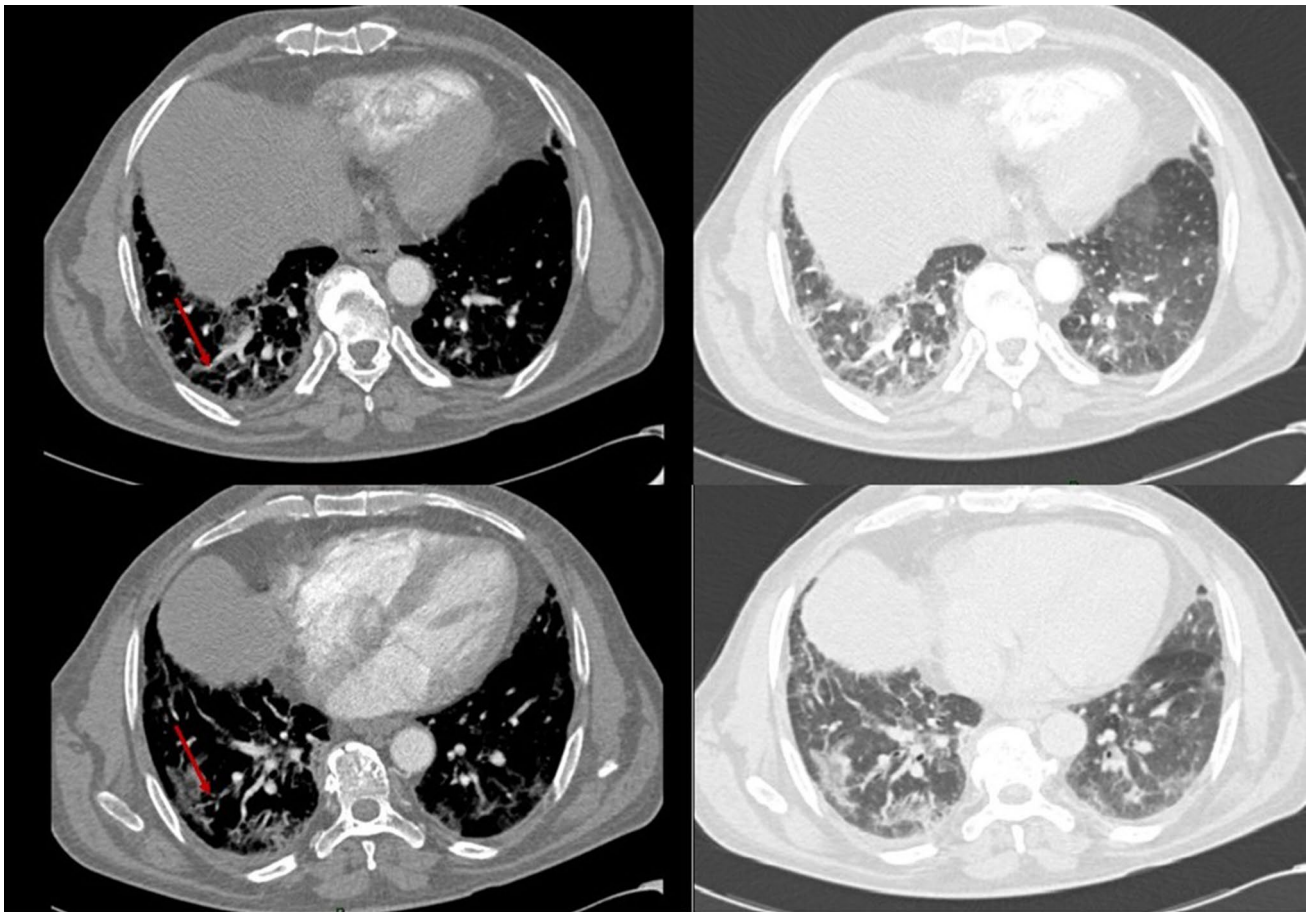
Patient's chest CT-scans. The left scans show sub-segmental thromboembolism (red arrows), localized in inferior right lobe (upper scan) and medial right lobe (lower scan). The right scans show the ground-glass opacities localized in the same areas
